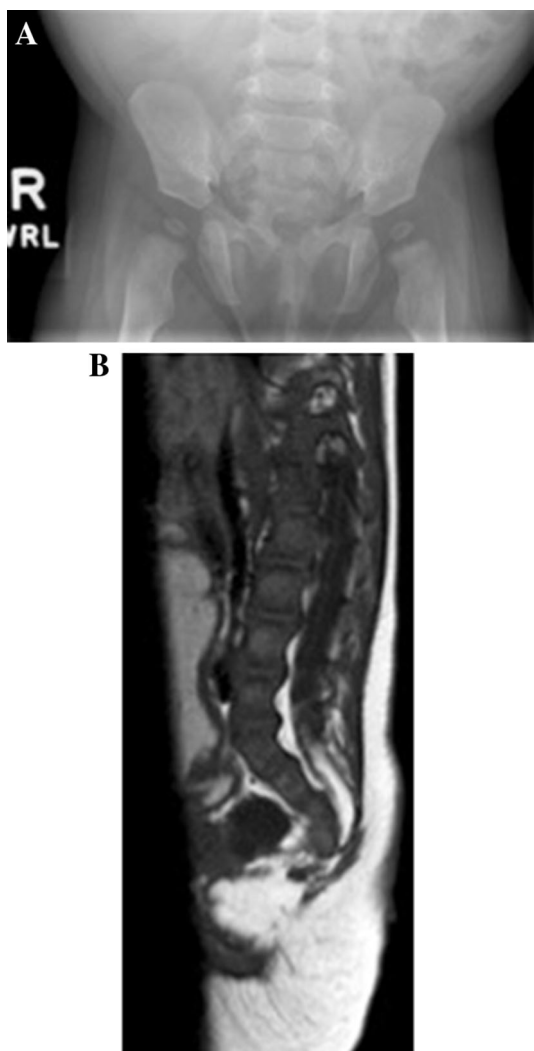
a AP radiograph sacrum demonstrating scimitar sacrum, b MRI spine demonstrating a pre-sacral mass
